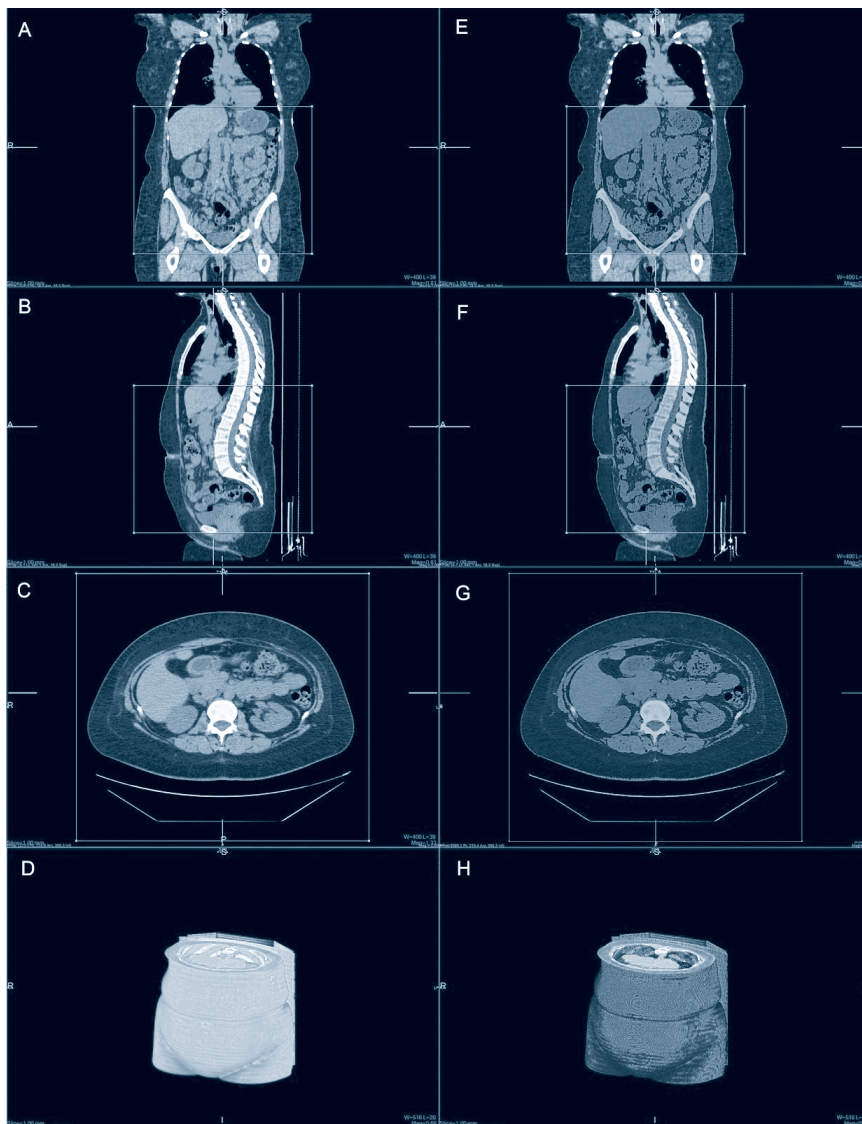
A Typical 2-D Snapshot of the 3-D Rendering from a CT Scan Using Novapacs® with Abdominal Fat Selected from the Top of the Liver to the Pubic Symphysis
